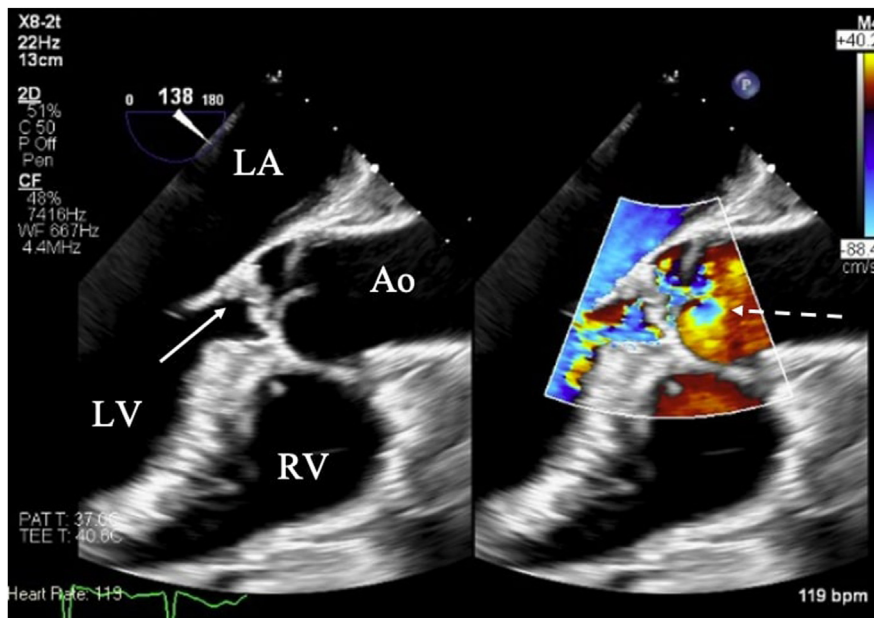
Two-dimensional TEE, midesophageal long-axis (138°) view without (left) and with (right) simultaneous color-flow Doppler, demonstrates the large aortic valve vegetation (solid arrow) with associated severe AR as demonstrated by the large Nyquist-limit adjusted flow convergence pattern (dashed arrow). Ao, Aorta; LA, left atrium.
